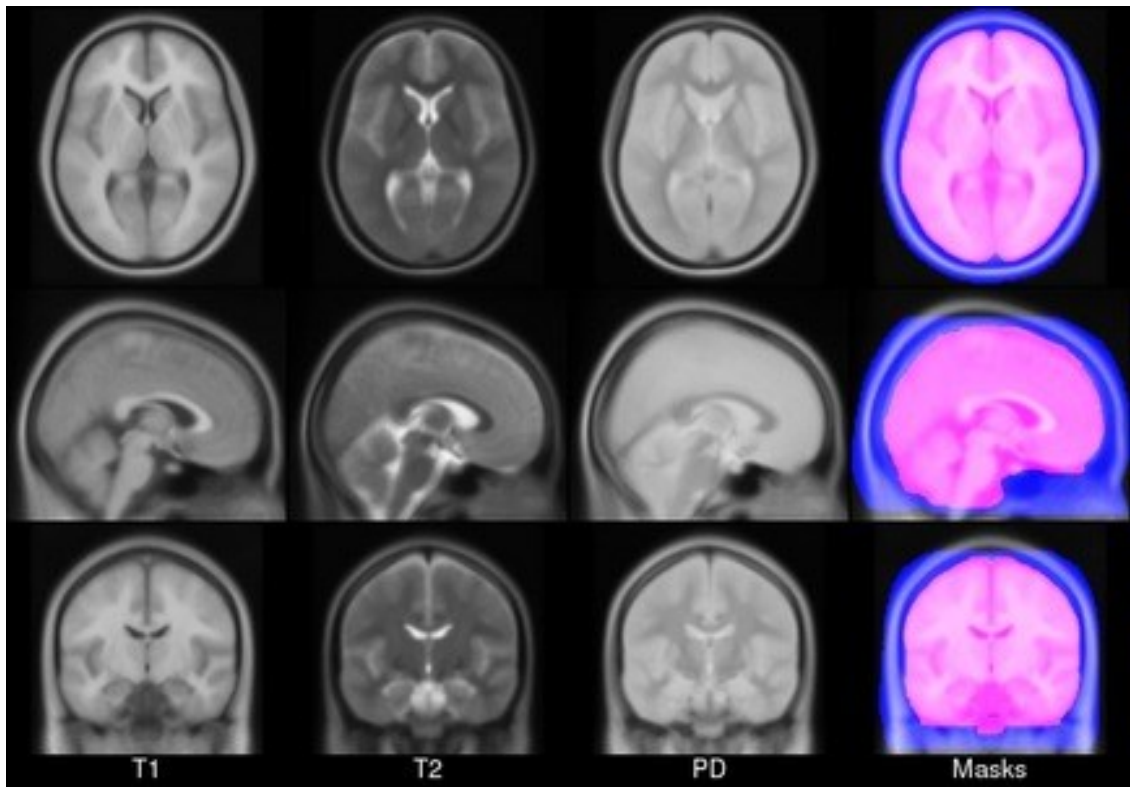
ICBM152 atlas[161]. From left to right, T1-based intensity-averaged MRI scans, T2-based intensity-averaged MRI scans, PD-based intensity-averaged MRI scans and the masks based on segmentation of brain tissue and non-brain tissue are shown in this figure.
